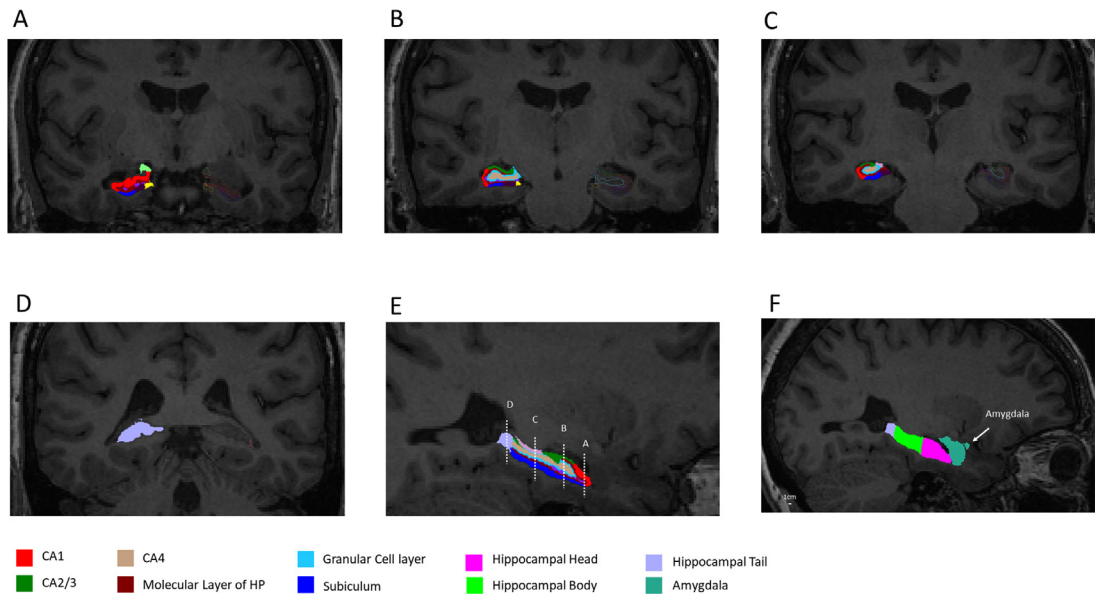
Automated hippocampal subfields segmentation for 47 TN responders and their age- and sex-matched healthy controls using FreeSurfer 6.0 and its developmental package. Hippocampal segmentation for an MRI scan delineated by FreeSurfer 6.0. A-D are coronal views. E and F are sagittal view.
